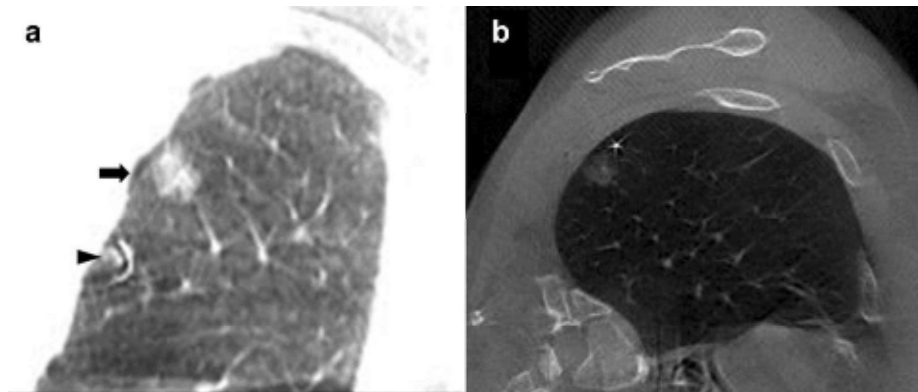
Second scan with the mobile computed tomography scanner confirmed the appropriate needle placement just above the target lesion
